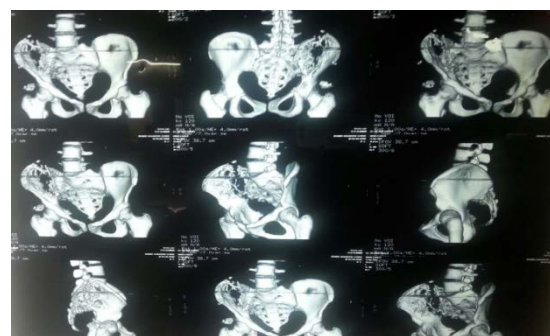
MRI of patient with primary iliac bone hydatid disease
